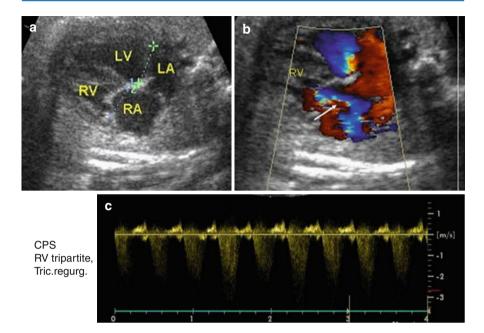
Case with critical pulmonary stenosis with good RV (a), tricuspid regurgitation at color Doppler till the top of the right atrium (RA) in blue -arrow (b), and holosystolic regurgitant flow at pulsed Doppler. LV left ventricle, LA left atrium (c) Doppler gradient across the tricuspid valve
